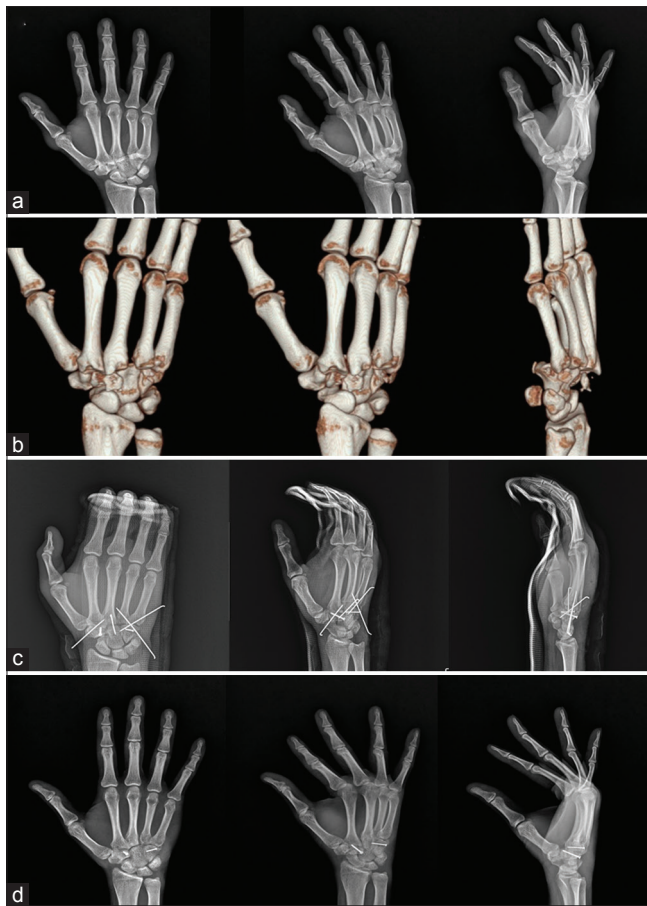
(a) Plain radiography showing concurrent carpometacarpal joint dislocation and fracture of the trapezoid and hamate; (b) Preoperative three-dimensional computed tomography images; (c) Postoperative radiography showing well-reduced carpometacarpal joints; (d) Plain radiography at 1-year followup
